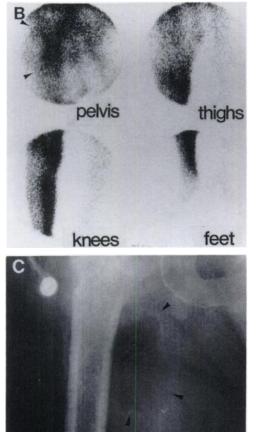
Patient 12, a 74-yr-old steroid-dependent male. Right psoas abcess percutaneously drained and positive for bowel flora. Progressive deterioration on multiple intravenous antibiotics. Indium-111-IgG demonstrated abscess and also unexpected activity throughout acutely swollen right lower extremity. Surgical exploration found extensive gangrenous necrosis. Massive debridement was attempted, but overwhelming septic shock followed. (A) CT with psoas abcess (arrow). (B) Indium-111-IgG 24-hr images with abcess site (arrowheads) and lower extremity activity. (C) Radiograph with soft-tissue gas (arrowheads).
